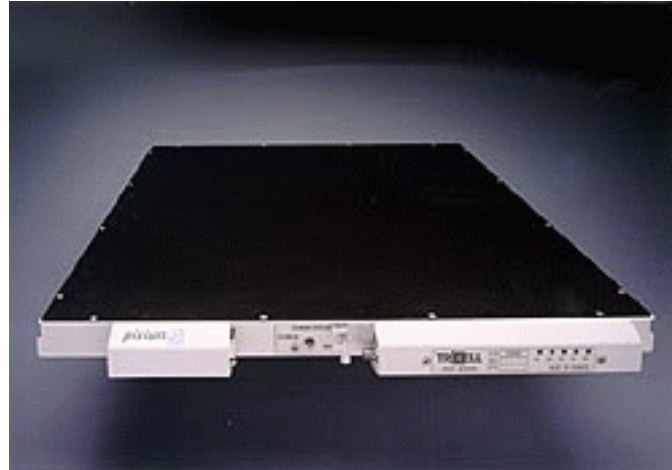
The Pixium 4600 digital X-ray detector from Trixell
